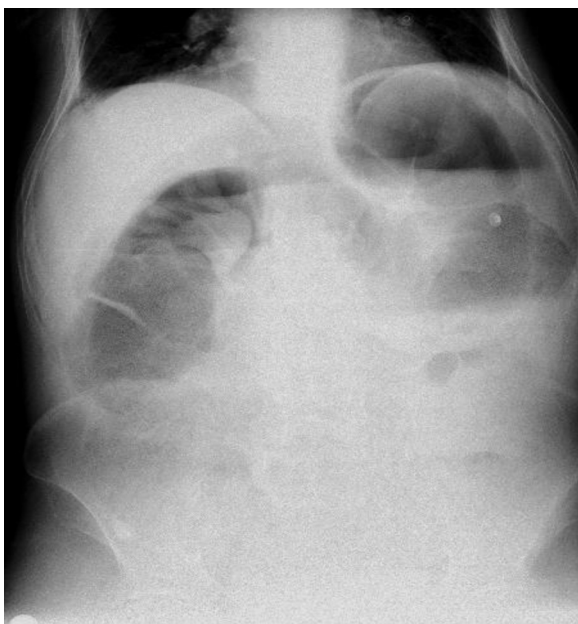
Radiograph shows colonic dilatation.
